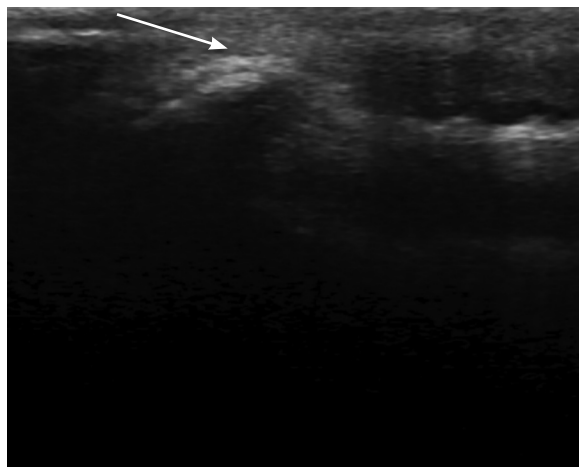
Ultrasound view showing a prominent external occipital protuberance in a pediatric patient.*
